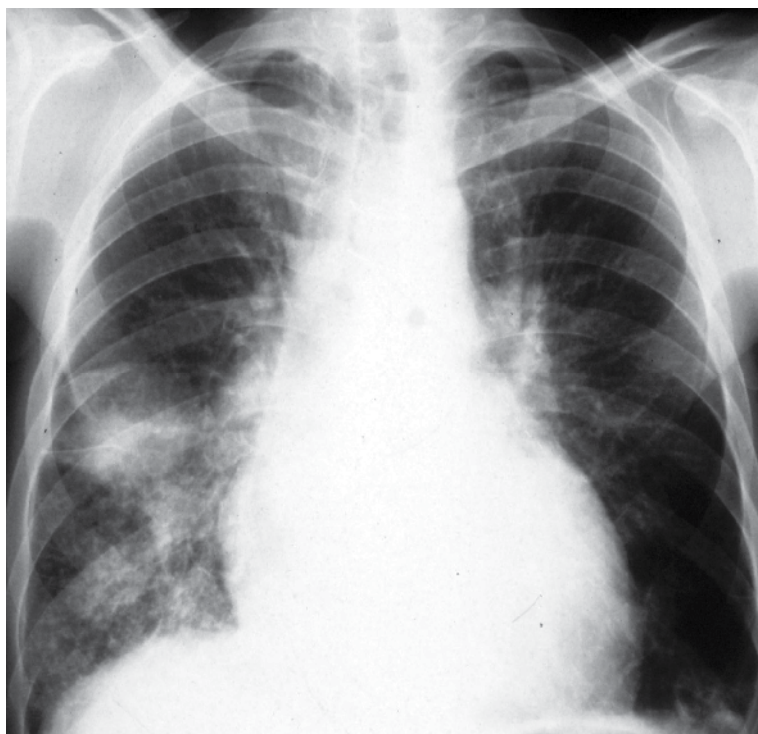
Diffuse alveolar hemorrhage in chest x-ray in Wegener's granulomatosis.
